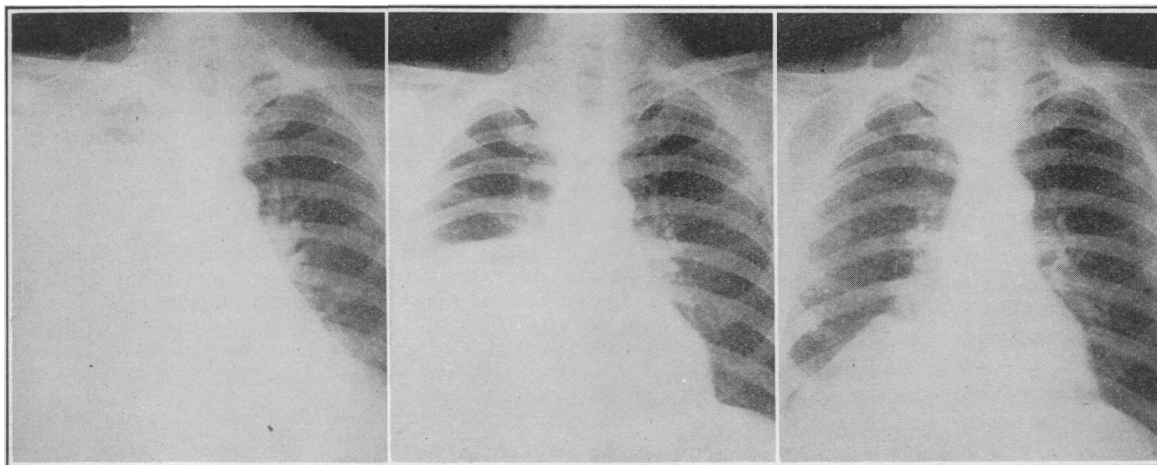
Roentgenogram made March 10, 1925, showing practically complete right hydrothorax, indicating circulatory obstruction caused by enlarged mediastinal lymph nodes.
